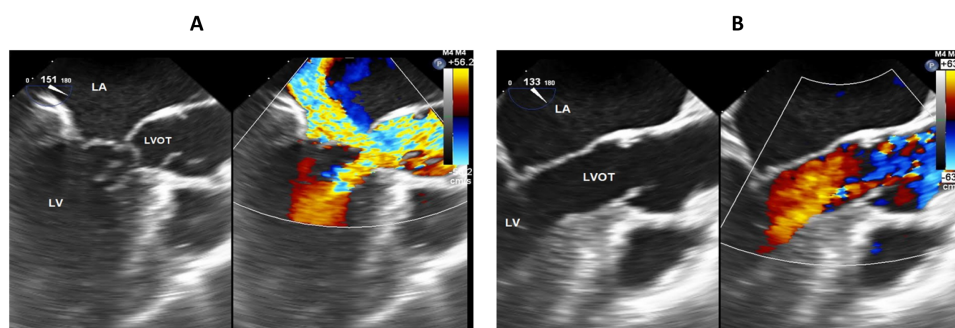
Pre- and post-myectomy TEE images. (A) Trans-esophageal echocardiography (mid-esophageal long axis view) showing the septal bulge of HOCM covered by a glistening endocardium denoting fibrosis, severe SAM with accessory chord attached to the interventricular septum. (B) Post-operative trans-esophageal echocardiography (mid-esophageal long axis view) of the same patient, showing laminar flow in the LVOT after the resection of the septal bulge and the accessory chord with the elimination of SAM. (TEE, transesophageal echocardiography; SAM, systolic anterior motion; LVOT, left ventricular outflow tract; LA, left atrium; LV, left ventricle)
